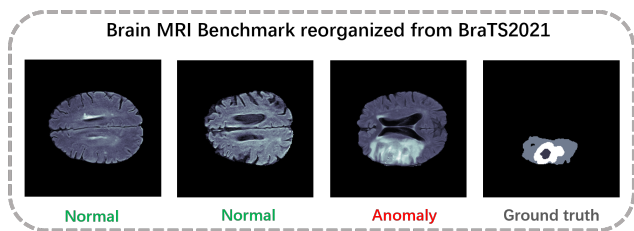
Visualization of our proposed Brain MRI benchmark.
